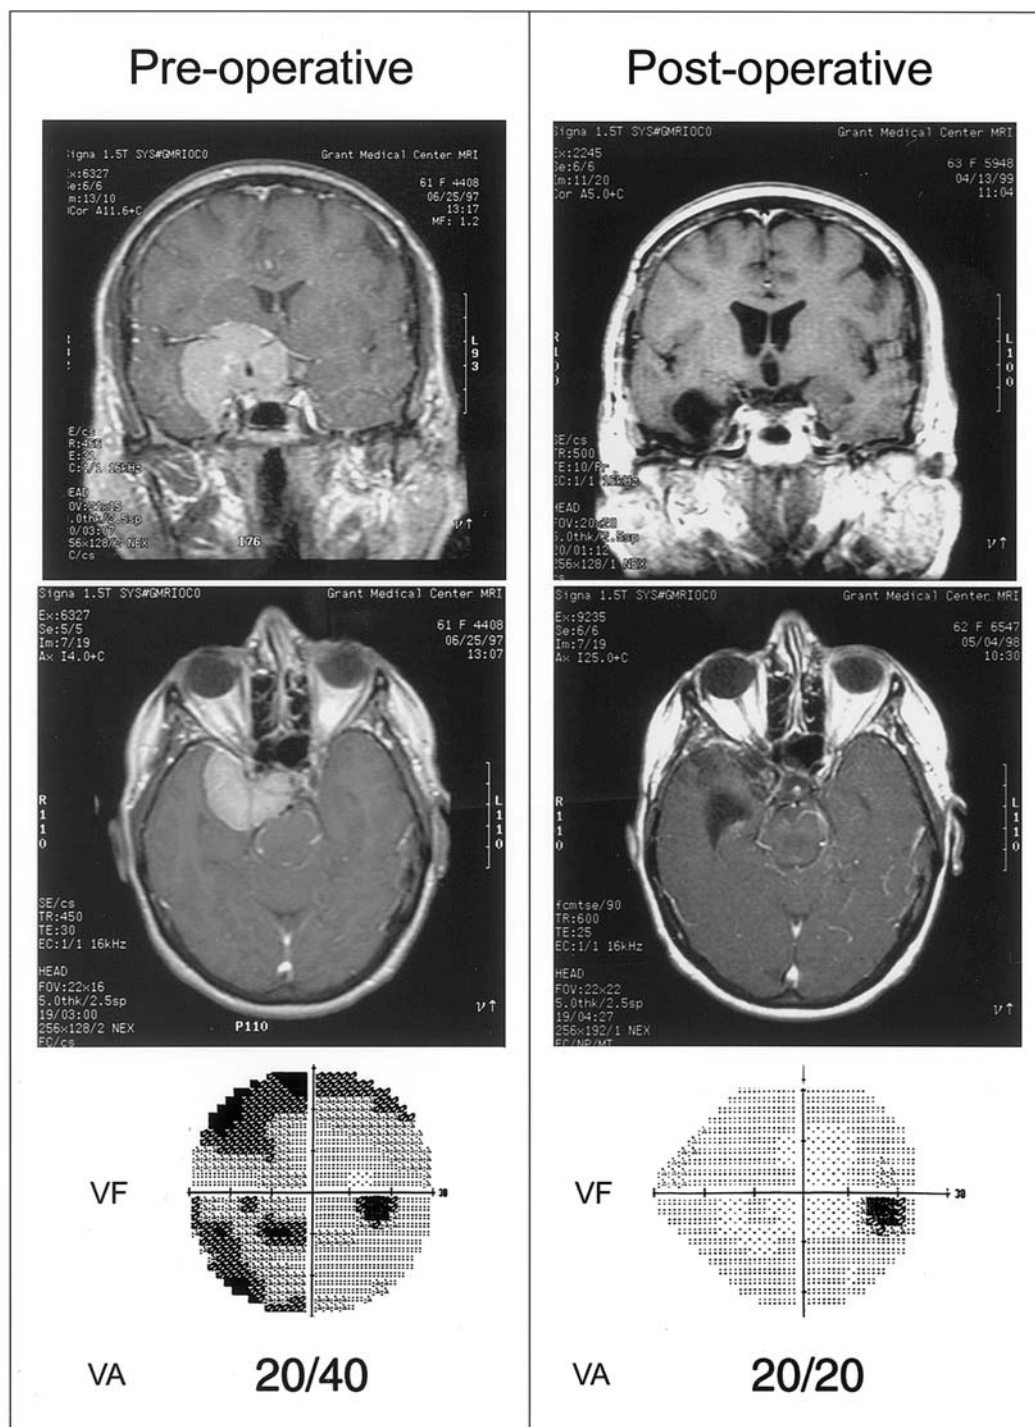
Coronal and axial gadolinium-enhanced T1-weighted MR images of a 61-year-old patient (left upper and left middle) presenting with decreased visual acuity (20/40) and visual field (superior and inferior arcuate defects) (left lower). Following total resection (right upper and right middle), her vision returned to normal (right lower). VA, visual acuity; VF, visual field.
